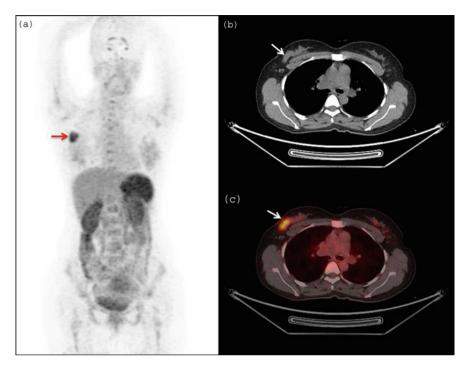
MIP PET image of 57-year-old female patient with breast carcinoma, 45 min post i.v. injection of $3-5 \text{ mCi}^{68}$ Ga-DOTA-RGD₂. (a) Abnormal tracer uptake was seen in right hemithorax which on CT and fused PET/CT transaxial images (b) and (c) localized to a moderately tracer avid (SUVmax 8.5) lesion in the upper outer quadrant of right breast
